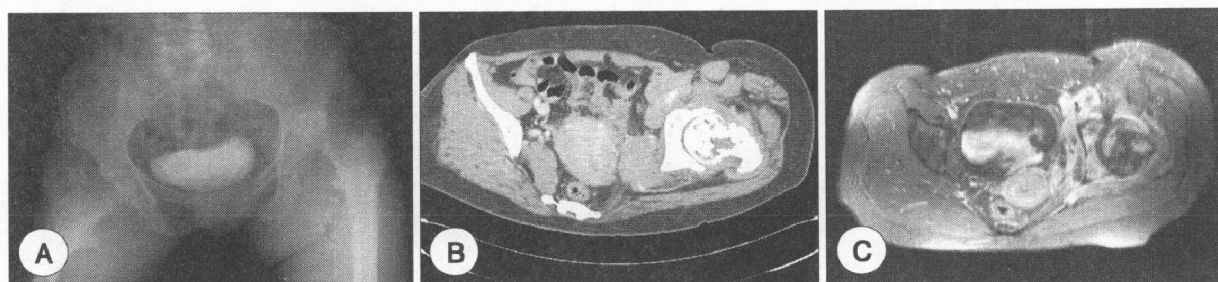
Radiologic findings. A : Conventional radiograph of the left hip joint showed features of secondary osteoarthritis, including severely decreased joint space, osteolysis, collapse of the femur head, and joint effusion. B : Computed tomography of the lower extremities showed a destructive left hip joint and soft tissue swelling. C : Magnetic resonance imaging of the left hip revealed similar changes resulting from secondary osteoarthritis in the hip joint and left acetabulum accompanied by changes suggestive of inflammation in the adjacent pelvic soft tissue.
